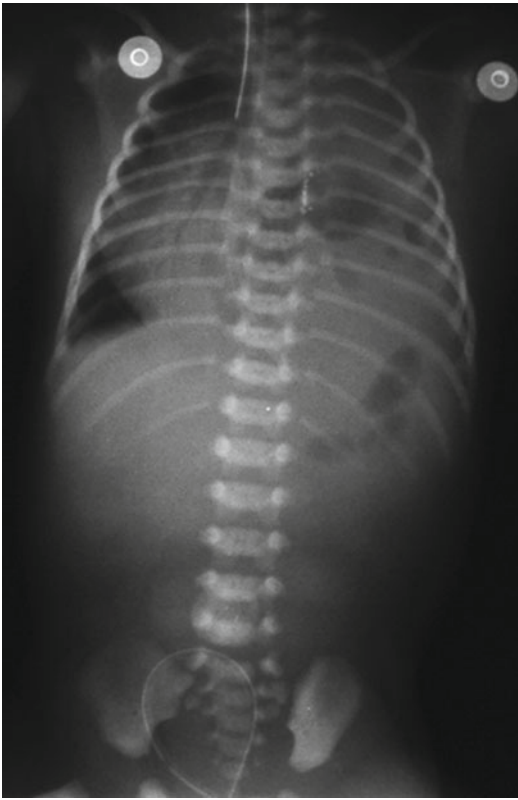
Plain radiograph shows herniation of the bowel in the left chest cavity, with displacement of the heart, in diaphragmatic hernia
